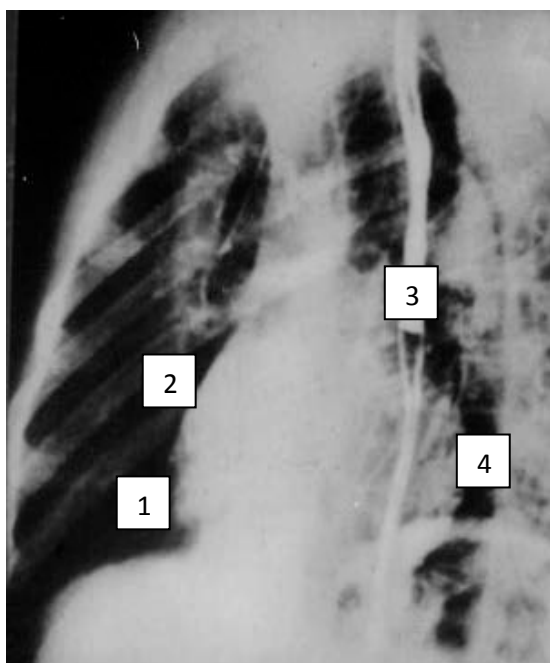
The heart radiograph in the left (second) oblique projection. 1 – right ventriculus arch, 2 – arch of the right atrium, 3 – arch of the left atrium, 4 – arch of the left ventriculus. Norm [31]
